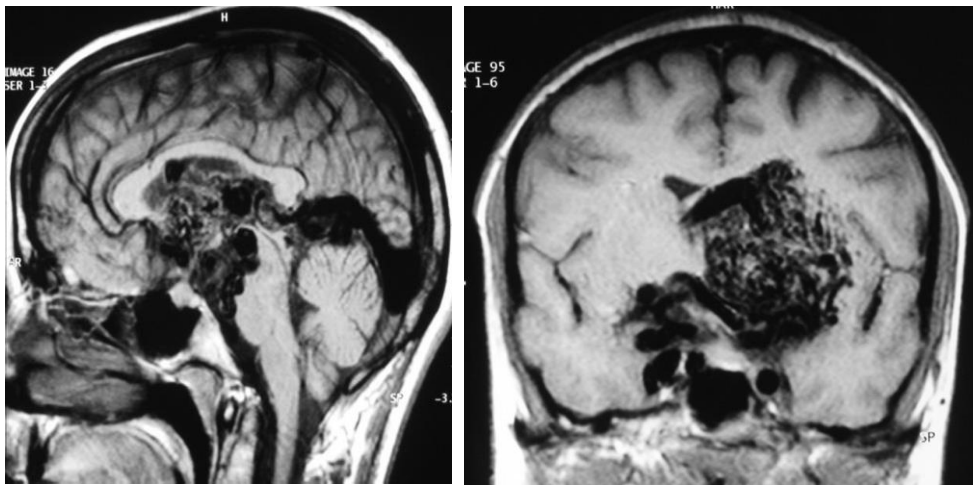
MRI image of a Grade V AVM. Figure courtesy of Professor Marcus Stoodley.
